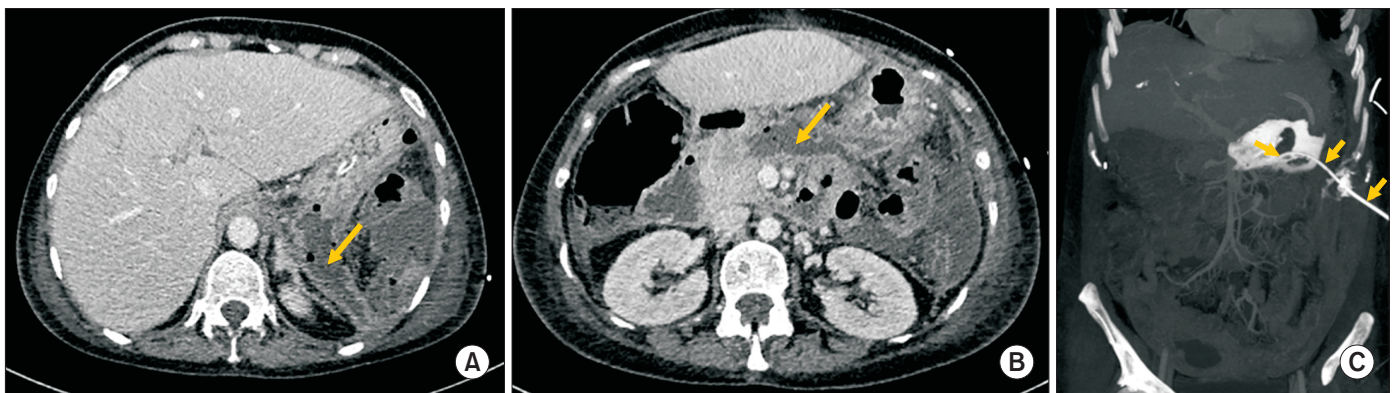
Follow-up computed tomography (CT) of the abdomen after placement of a percutaneous pigtail catheter. The percutaneous drainage was inserted through the left hypochondrium and flank, with the distal tip positioned within the retroperitoneal peripancreatic collection. (A, B) Axial CT images in the portal phase. Orange arrows indicate the residual collection following placement of the pigtail drainage catheter. (C) Coronal maximum intensity projection reconstruction in the portal phase. Orange arrows show the position of the drainage catheter within the collection.
